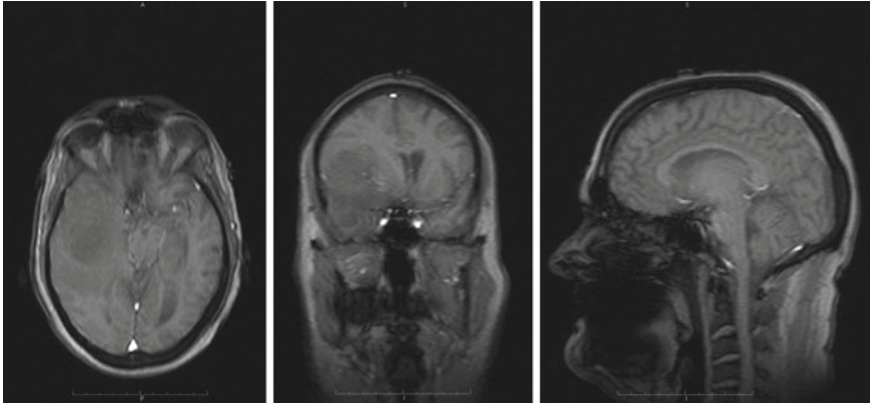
One patient brain MRI scan
